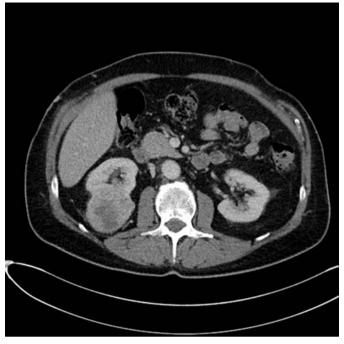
CT showing an incidental lesion on the right kidney, likely the source of the metastatic deposit
